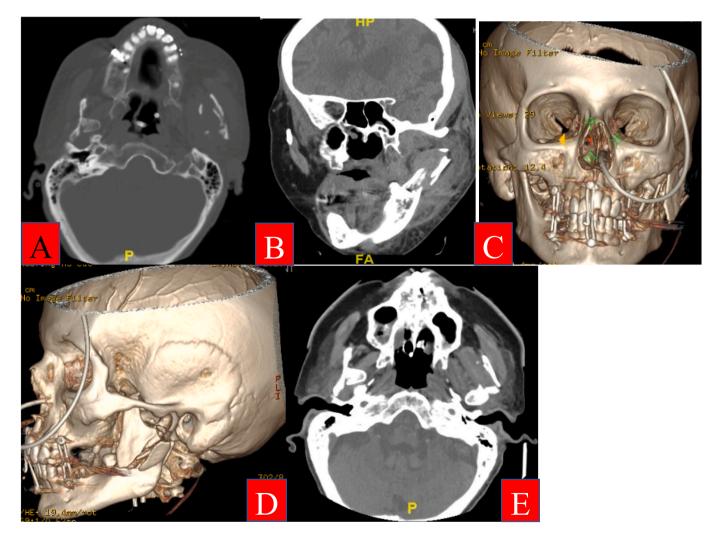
Admission Head CT and 1st follow up Facial CT with 3D reconstruction after maxillomandibular fixation. (A) Axial CT shows bilateral displaced mandible fractures. (B) Marked soft tissue swelling of left maxillary and mandibular regions (C, D) 3D reconstruction shows fixation of mandible after initial surgical intervention. (E) Significant swelling decrease after course of steroids.
